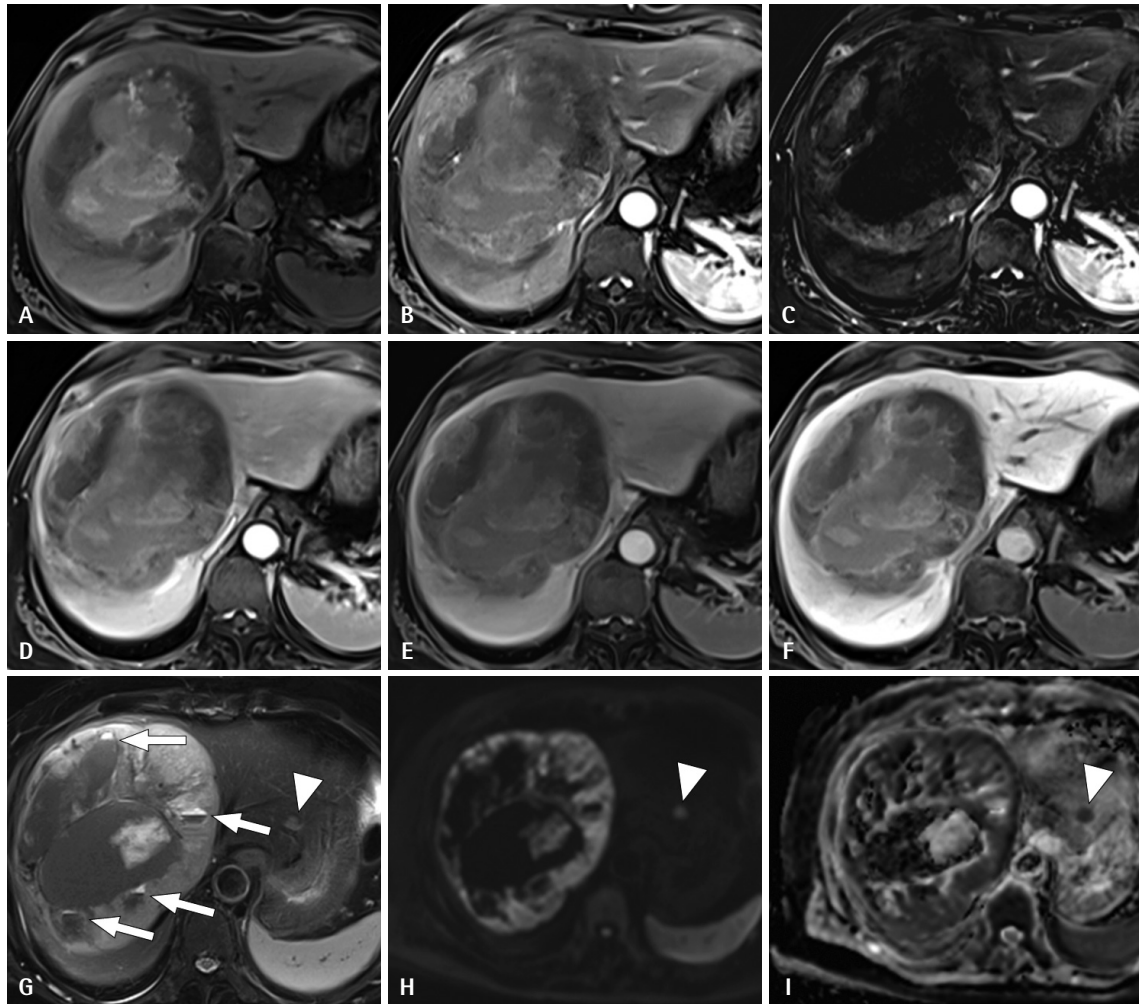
Gadoxetic acid-enhanced magnetic resonance imaging (MRI) findings of the liver masses. Gadoxetic acid-enhanced MRI with pre-contrast (A), arterial (B), arterial subtraction (C), portal (D), transitional (E), and hepatobiliary (F) phases, T2-weighted images (G), diffusion-weighted images ($b = 800 \text{ s/mm}^2$) (H), and apparent diffusion coefficient map (I). The large mass involving liver segments 4 and 8 showed low signal intensity with foci of high signal intensity in the pre-contrast T1-weighted image (A), suggesting focal hemorrhage. The mass shows heterogeneous arterial hyperenhancement (B, C), washout in the portal phase (D), and low signal intensity in the transitional and hepatobiliary phases (E, F). The central area of the large mass is not enhanced, suggesting necrosis. In the T2-weighted image (G), the large mass exhibits heterogeneous intensity with a central necrotic area and several foci at the fluid-fluid level (arrows). On diffusion-weighted imaging, the mass lesion shows diffusion restriction (H, I). There was another tiny nodular lesion in liver segment 2, with moderate hyperintensity in the T2-weighted image and diffusion restriction (arrowheads) (G-I).
